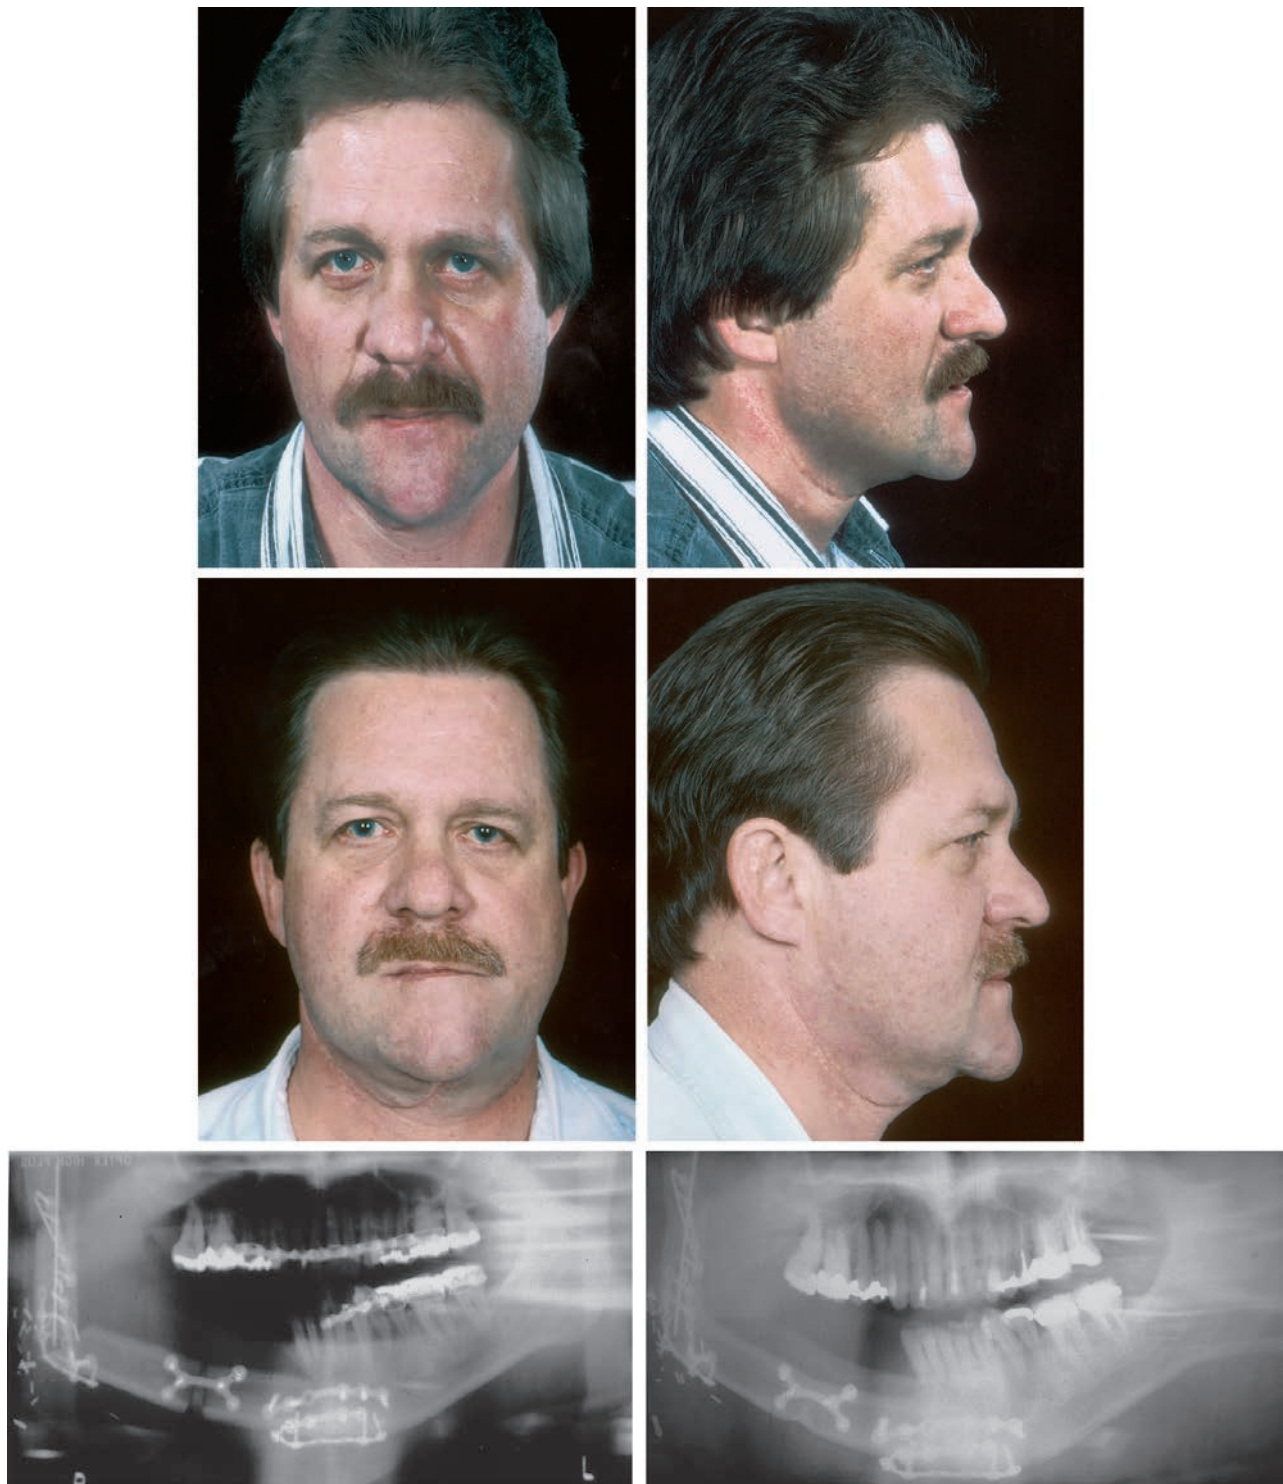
Patient 2 in Tables I and II. (*Above*) Postoperative views at 2 years 4 months. (*Center*) Postoperative views at 13 years 4 months. (*Below, left*) Early postoperative Panorex radiograph. (*Below, right*) Panorex radiograph at long-term follow-up shows healed osteotomies and maintenance of bone height.
